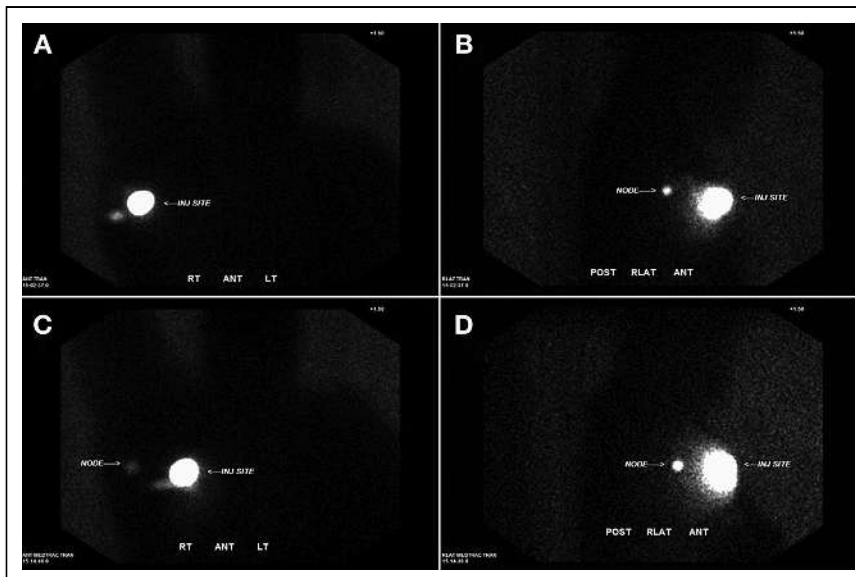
(A and B) Anterior (A) and lateral (B) ^{99m}Tc -tilmanocept lymphoscintigraphy transmission images demonstrate focal area of increased uptake superior and posterior to injection site on lateral view. Focus of uptake inferolateral to injection site on anterior view is in lower position than uptake on lateral view in relation to injection site, suggesting it may not correspond to uptake on lateral view. (C and D) Repeat anterior (C) and lateral (D) images during medial breast traction by patient displaces superimposed injection site medially and clearly demonstrate sentinel node in axillary region on anterior view. Focal uptake inferolateral to injection site on anterior view is likely secondary to contamination.
